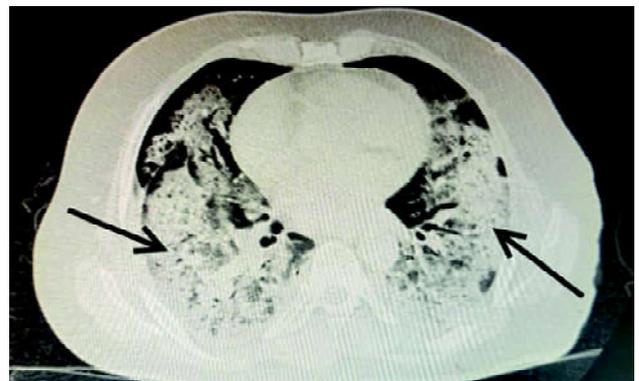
CT Massive multi-lobar consolidation (black arrows) with air bronchogram.
